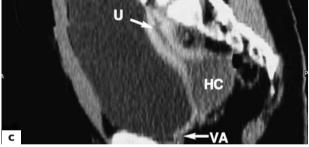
(a) Computed tomography reveals hematocolpos. (b) It has been found to be associated with uterine septum. (c) Magnetic resonance imaging reveals partial vaginal atresia (VA), hematocolpos (HC) and the uterus (U)
